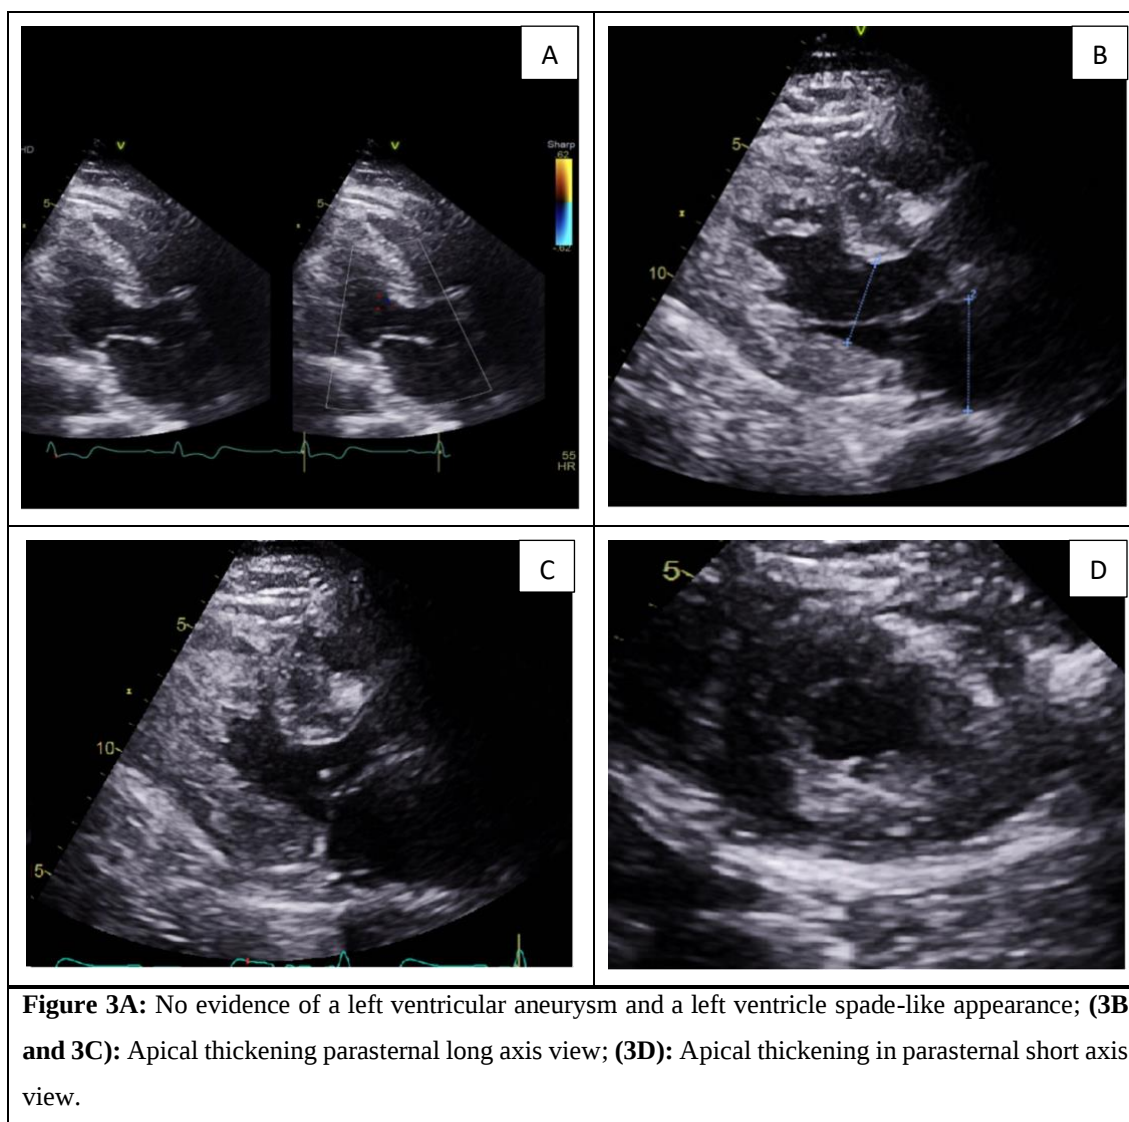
No evidence of a left ventricular aneurysm and a left ventricle spade-like appearance; (3B and 3C): Apical thickening parasternal long axis view; (3D): Apical thickening in parasternal short axis view.
